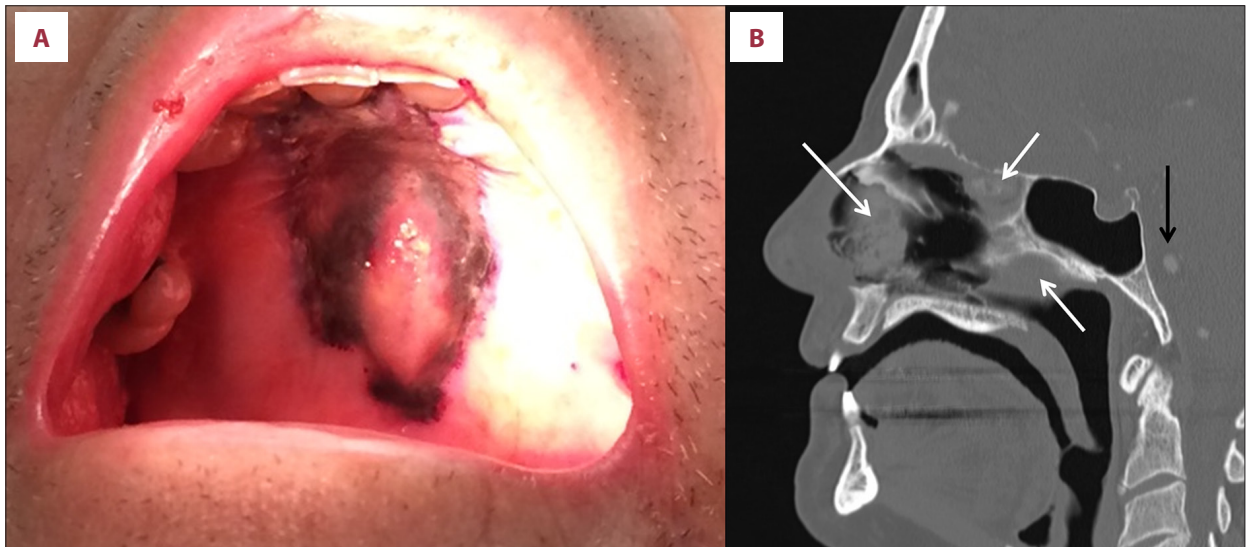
Clinical imaging: (A) black eschar on the hard palate shortly after tooth extraction; (B) magnetic resonance imaging of the head showing rhino-orbital sinus masses consistent with mucormycosis (white arrows) and mycotic embolus in the brain (black arrow).
